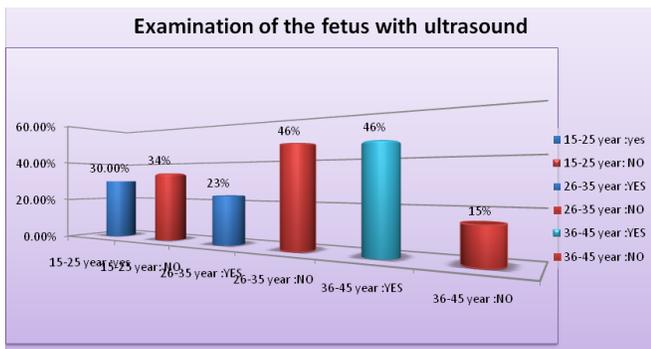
The percentage ratio of examination of the fetus with ultrasound in participant females.
